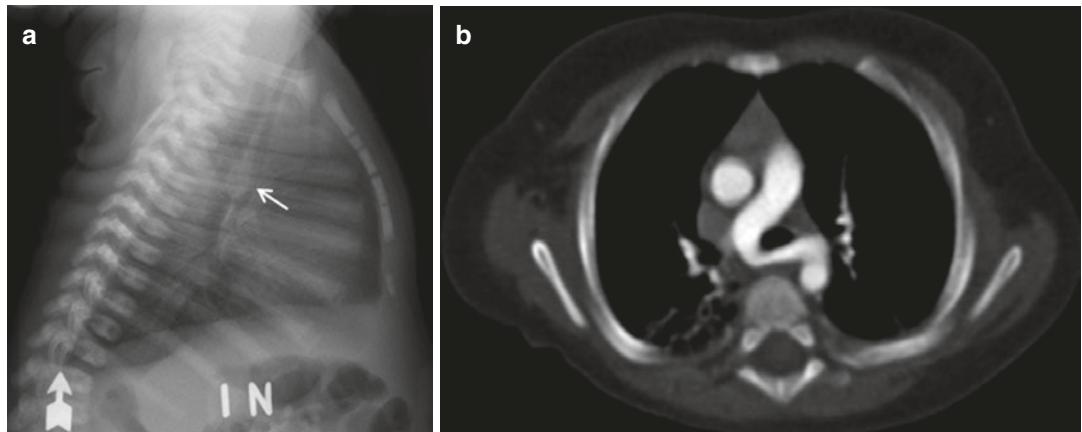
(a) Lateral chest radiograph of a 7-month-old girl with a well-defined oval opacity between the trachea and air-filled esophagus (arrow). (b) CT confirmed a pulmonary sling
